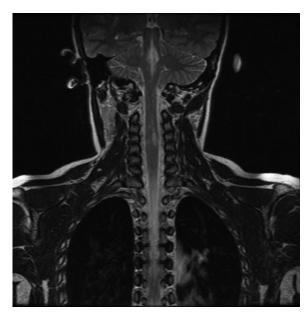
Coronal T2-weighted MRI image. Demonstrates abnormal T2 signal on the left extending caudally from the inferior medulla to C4.
